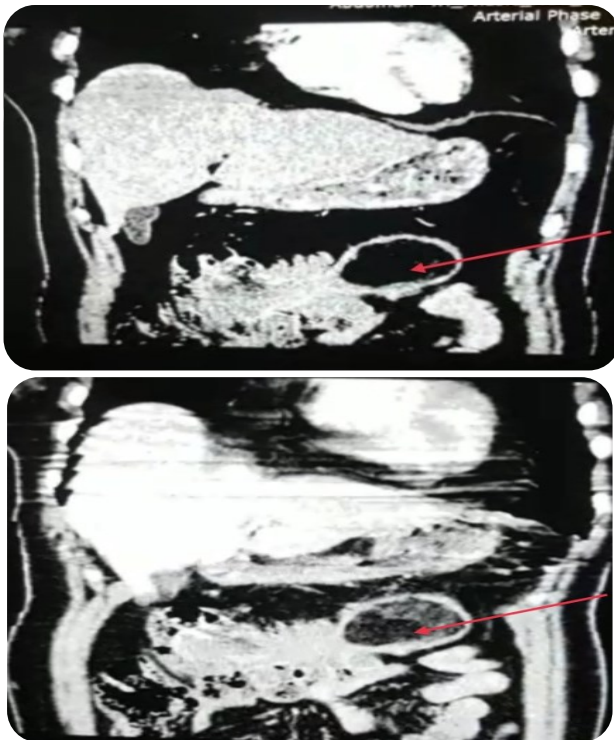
Triphasic CT Scan Abdomen (Arterial and Venous Phases)
